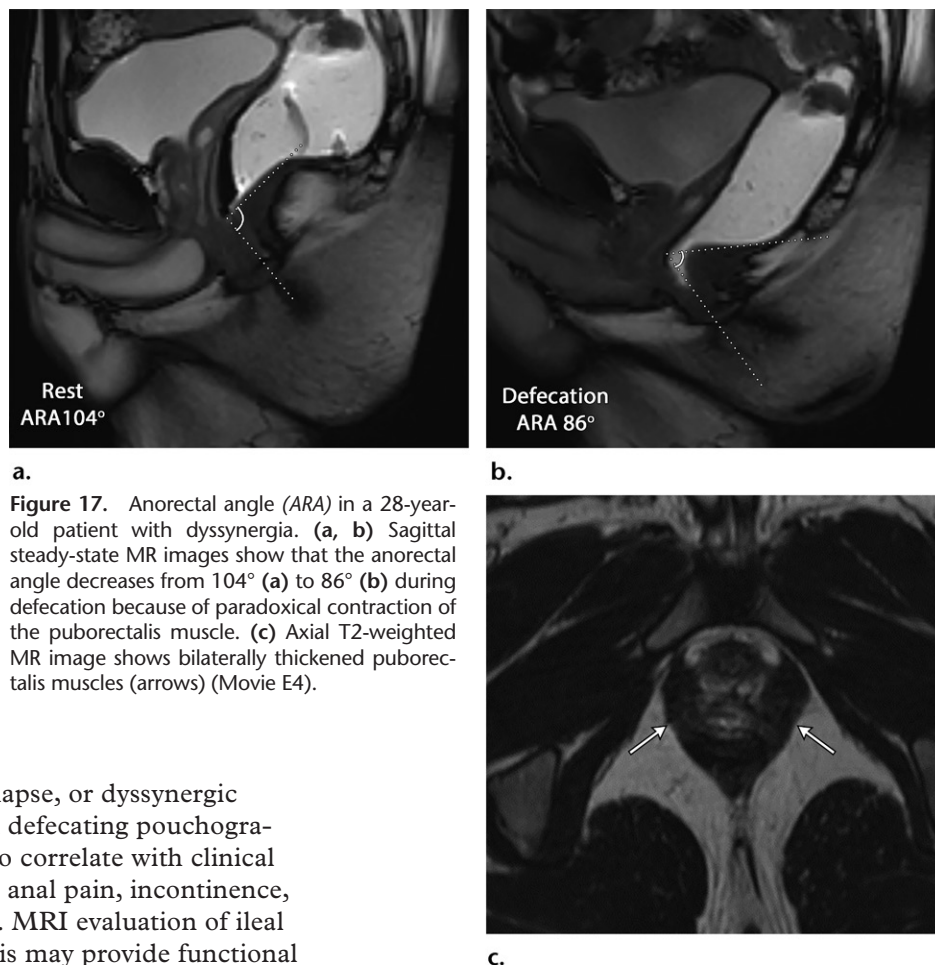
Anorectal angle (ARA) in a 28-year-old patient with dyssynergia. (a, b) Sagittal steady-state MR images show that the anorectal angle decreases from 104° (a) to 86° (b) during defecation because of paradoxical contraction of the puborectalis muscle. (c) Axial T2-weighted MR image shows bilaterally thickened puborectalis muscles (arrows) (Movie E4).
